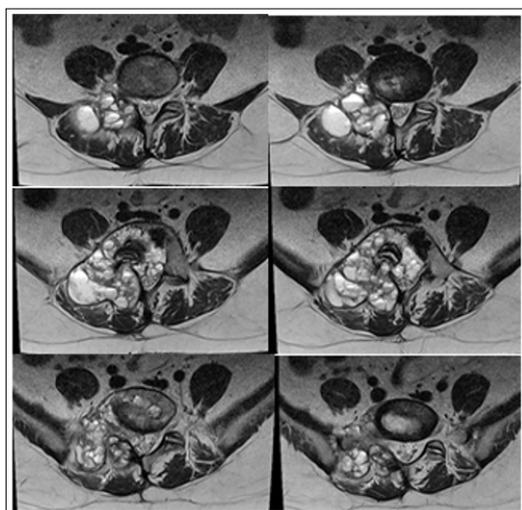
Spine MRI /March 2023
